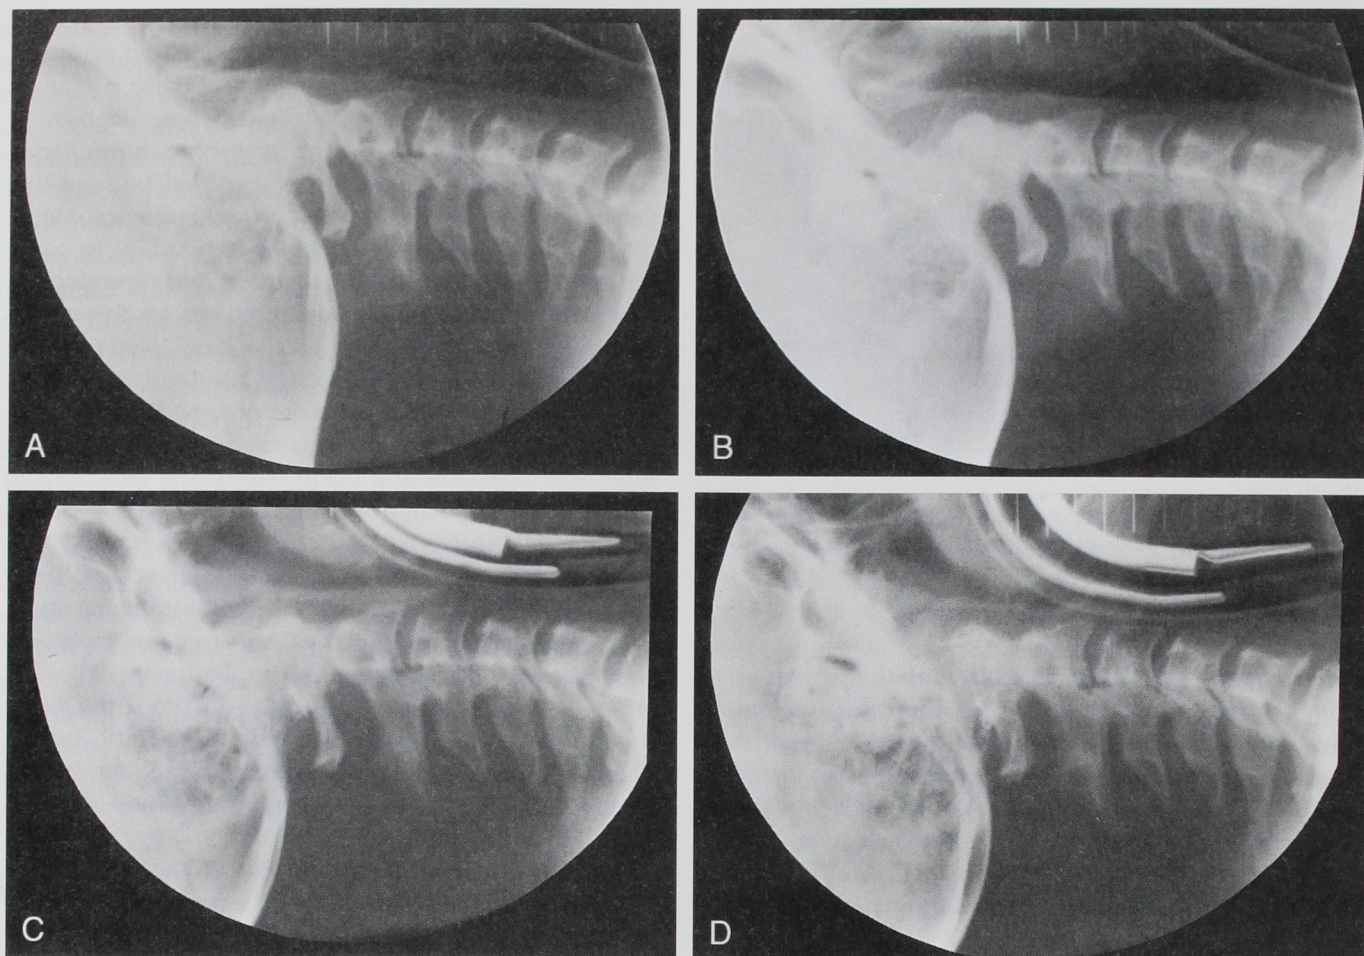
Radiographs representative of the extension seen during laryngoscopy using the Macintosh and Bullard laryngoscopes with and without manual in-line stabilization (ILS). (A) Macintosh, (B) Macintosh with ILS, (C) Bullard, and (D) Bullard with ILS.
